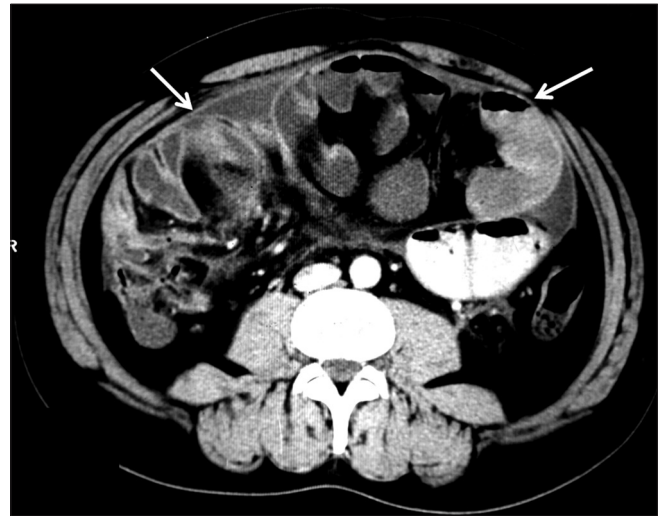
Idiopathic abdominal cocoon in a 24-year-old girl - axial contrast-enhanced computed tomography scan showing membrane (arrows) encapsulating the jejunal loops
